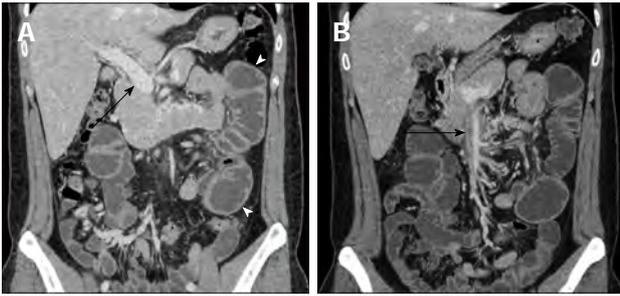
Abdominal computed tomography at second admission. A: Dilated proximal jejunal loop (arrow heads) and resolution of thrombus in the main portal vein (arrow); B: Remnant thrombus in superior mesenteric vein (arrow).
